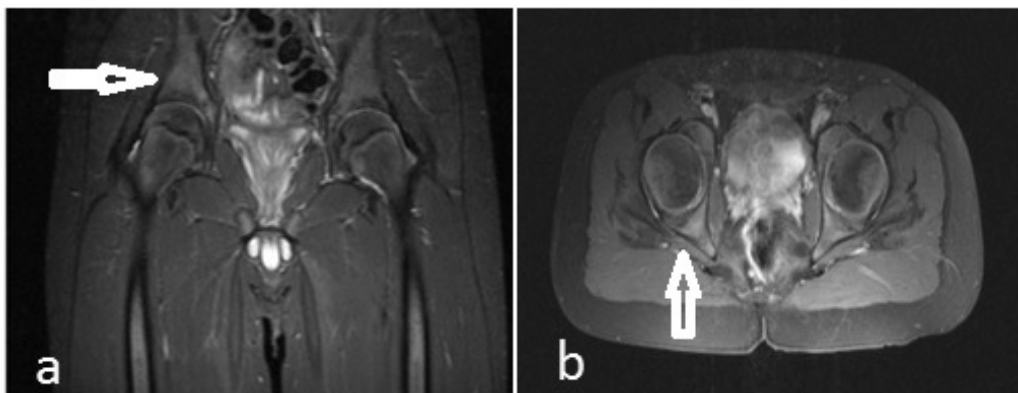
Magnetic resonance imaging: T1 TIRM sequence in coronal plane (a) and T1 SE with FS in axial plane (b) of the pelvis taken at 2 months after hospitalization. It shows resolution of right acetabular changes (arrows)
